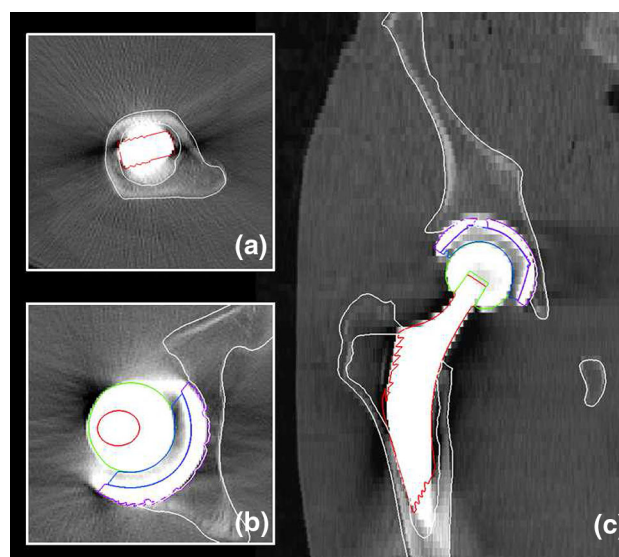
Example of segmentation of a post-operative CT image by rigid registration of pre-operative models, whose contours are overlaid on a–b axial and c coronal slices. Our constrained registration is particularly useful in regions with strong metallic artifacts, exemplified in the axial slices
